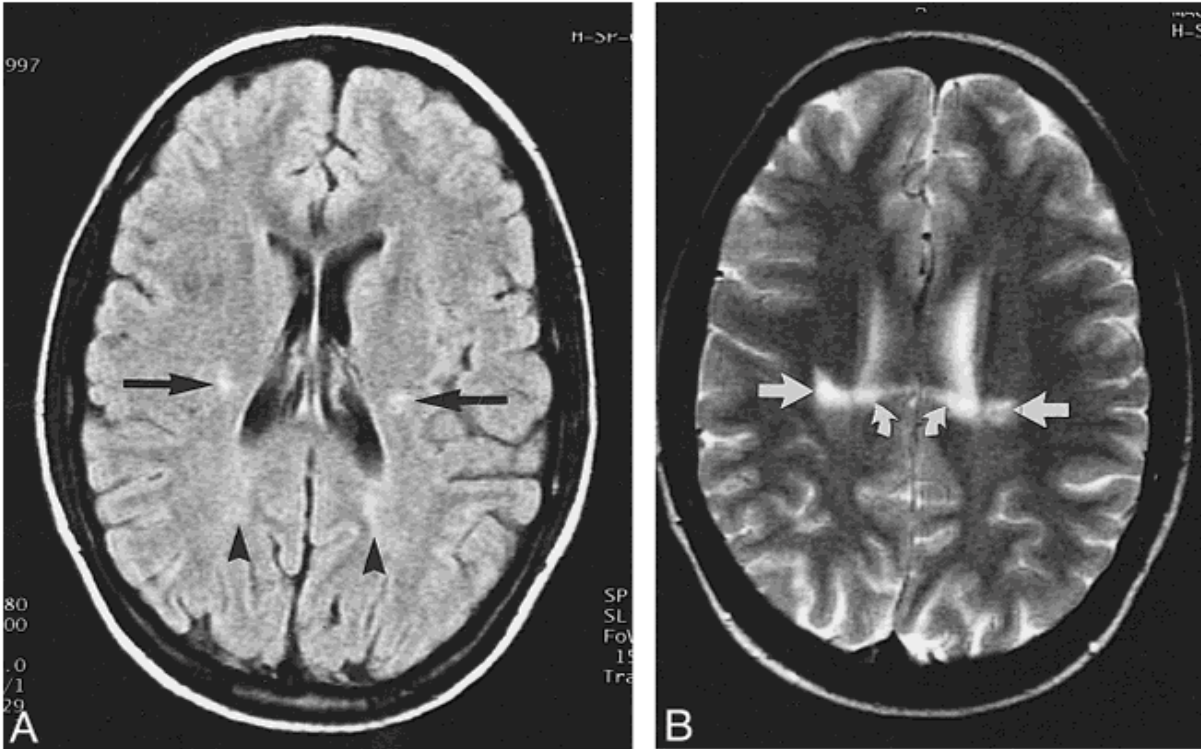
Axial MRI showing white matter signal abnormality
